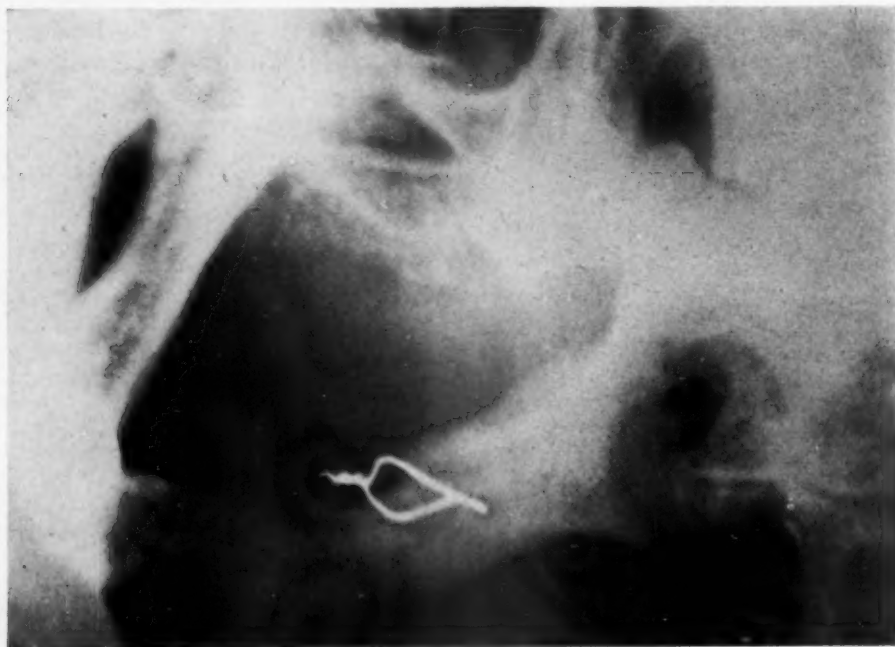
X-ray showing intraoral transosseous wiring with poor alignment resulting in permanent anesthesia and paresthesia in the parts supplied. Removal of the wire and nerve repair brought prompt relief. Note termination of mandibular canal over alveolar ridge.
